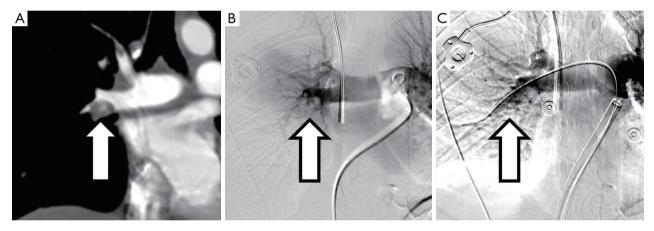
A 46-year-old woman with history of metastatic colon cancer presented with bilateral segmental pulmonary emboli within the lower lobes, greater in the right (A, arrow). She was determined to be a high-intermediate risk with tachycardia, elevated troponin-T and BNP, and enlarged right ventricle on CT-angiogram. Catheter directed angiogram confirmed absence of blood flow to the bilateral lower lobes (B, arrow demonstrates right segmental artery cut off) and main pulmonary artery pressure measured 25 mmHg. Mechanical thrombectomy was performed bilaterally with restoration of the blood flow (C, arrow demonstrated reconstituted right pulmonary artery). BNP, b-type natriuretic peptide; CT, computed tomography.
